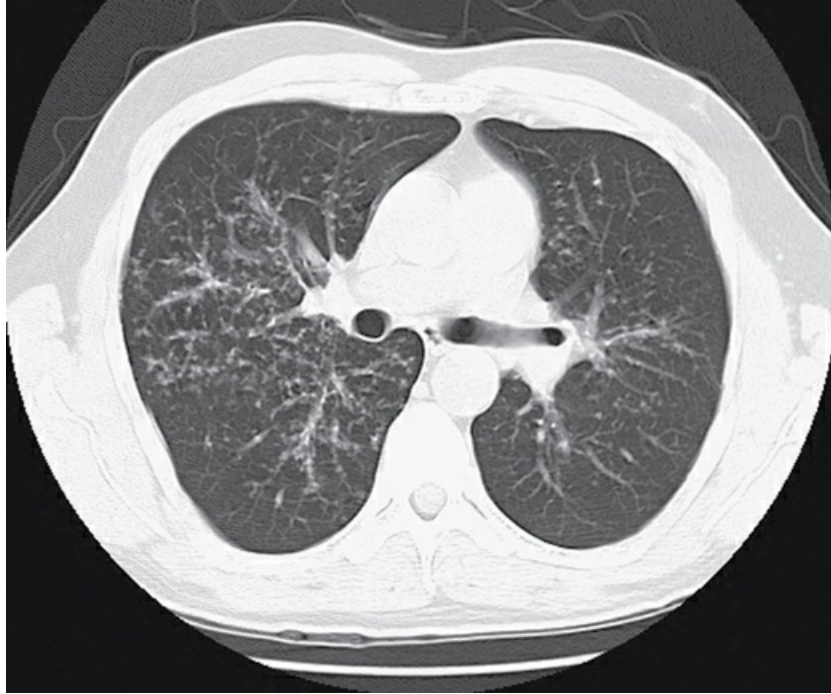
Chest computed tomography scan demonstrates micronodular pattern in a patient with sarcoidosis.
